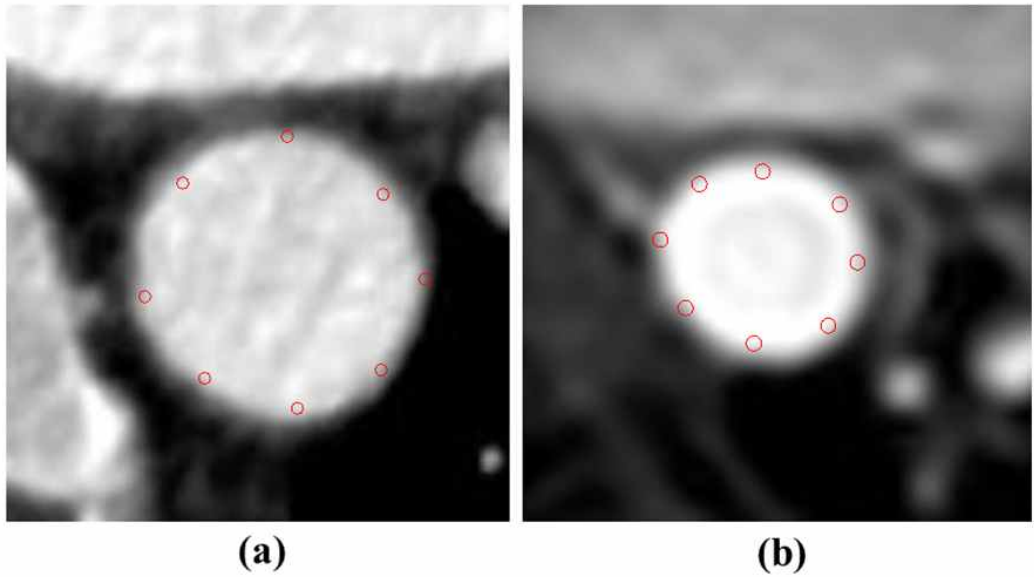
Initial pointing of wall boundary (A) aorta in MDCT image (b) aorta in MR image
